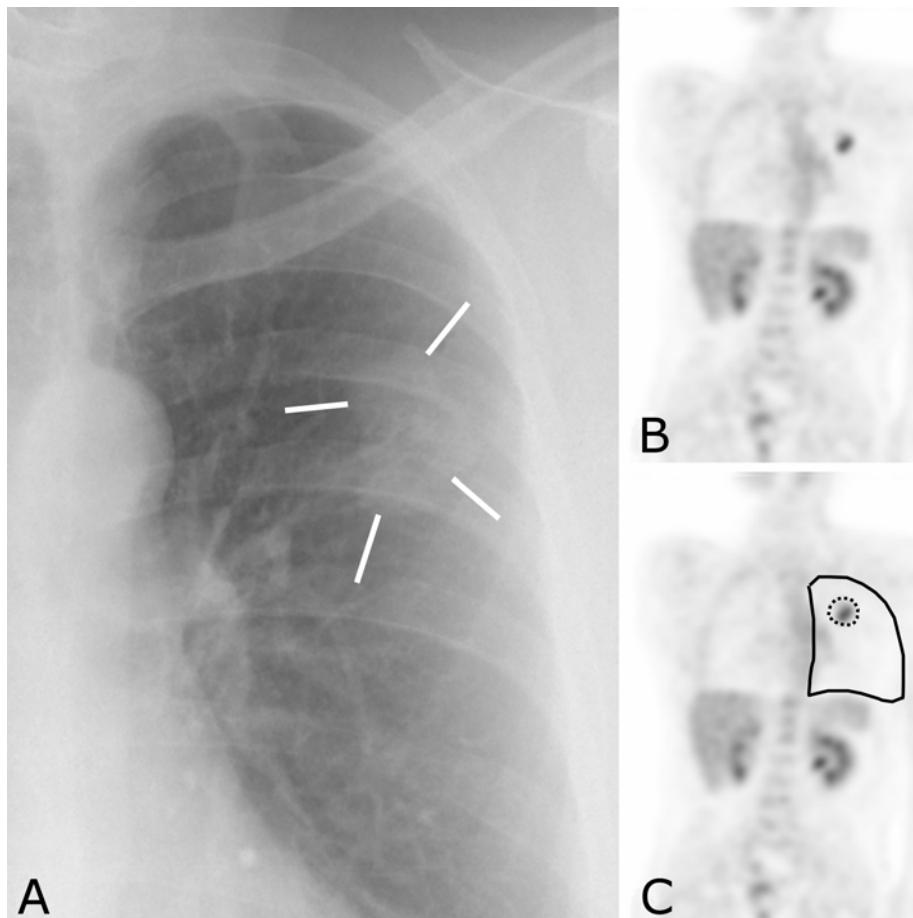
Hypermetabolic solitary pulmonary nodule. A. Frontal radiograph shows a solitary pulmonary nodule (white lines). B. Unmarked coronal PET image of the thorax. C. Marked PET image shows the abnormality – a “hot” focus (black dots) in the lung. For clarity, the margins of the left lung are indicated with a black outline.
